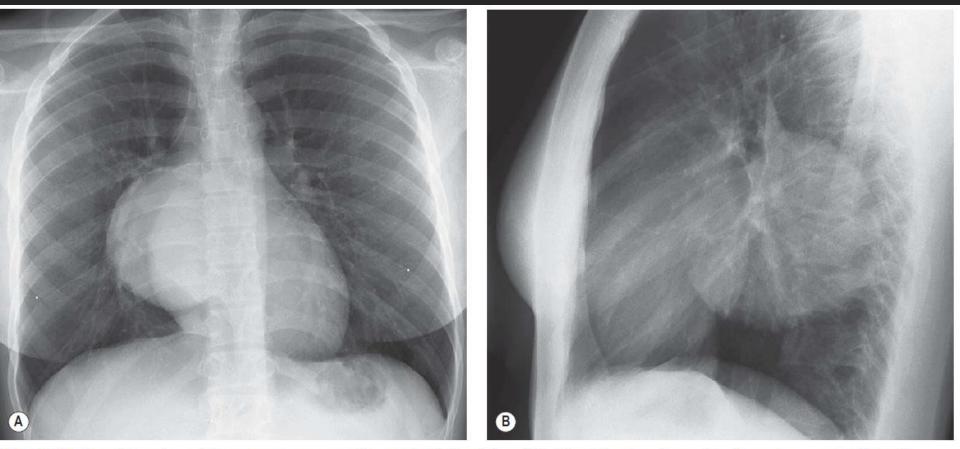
Bronchogenic cyst in a young woman with cough. A, Frontal and B, lateral chest radiographs show a large, smooth, wellmarginated mass in the middle mediastinum – the most common location for a bronchogenic cyst.
